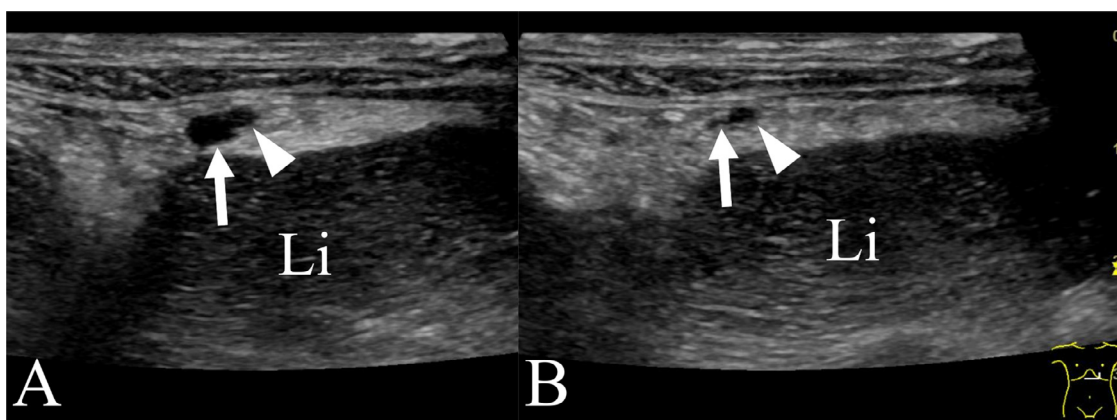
Abdominal ultrasound image of an omental vein. (A) Ultrasonography reveals that the omental vein (arrow) runs between the peritoneum and liver surface. A small artery (arrowhead) is observed next to the vein. (B) With compression using the ultrasound probe, the vein (arrow) is flattened. The artery (arrowhead) next to the vein keeps its shape. Li, liver.
